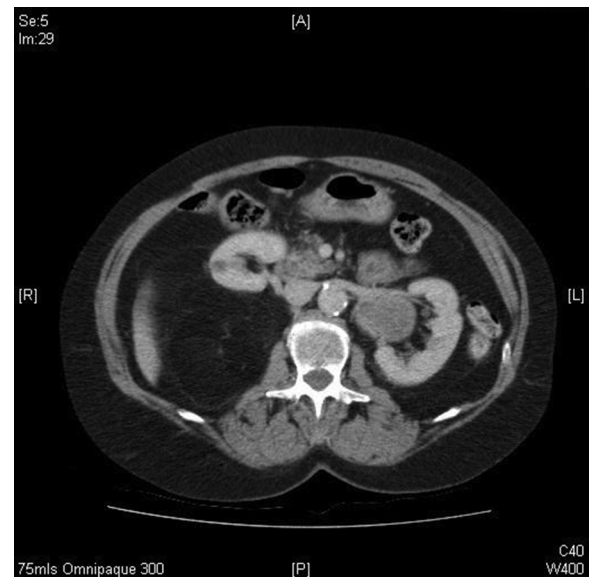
Axial CT showing mass lesion at the left renal hilum and a right retroperitoneal fatty mass.
